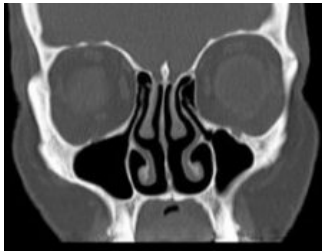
CT scan nose and sinuses in a patient with atrophic rhinitis
